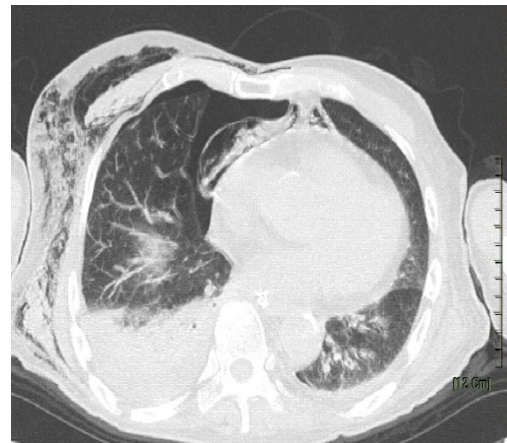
Computed tomography showed the presence of right pneumothorax, pneumomediastinum, and diffuse neck and chest wall emphysema.
